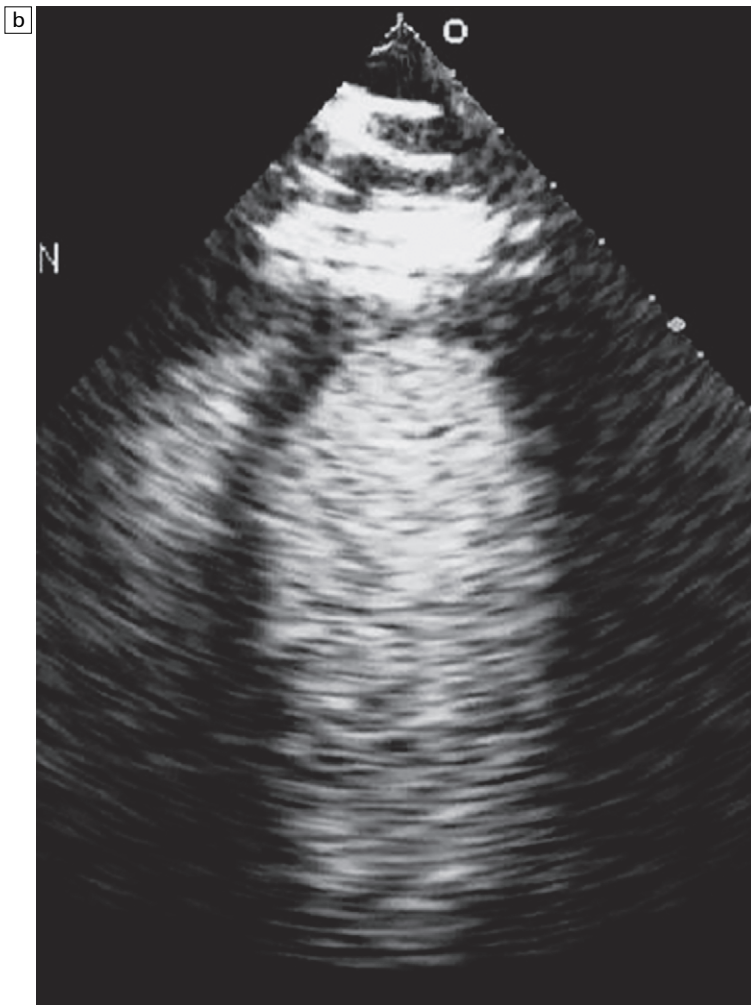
cont'd Before proceeding to perform a transoesophageal echo a microbubble contrast study was performed using a 0.3 mL injection of Optison® through an existing intravenous line and power modulation low mechanical index contrast imaging (b). Evaluation of the LV endocardial border was significantly enhanced, especially at the apex and the lateral wall, allowing an accurate assessment of LV function without needing to proceed to a transoesophageal echo. The improvement in image quality was even more evident on real-time images than on these still frames. (Copyright MJ Monaghan).
